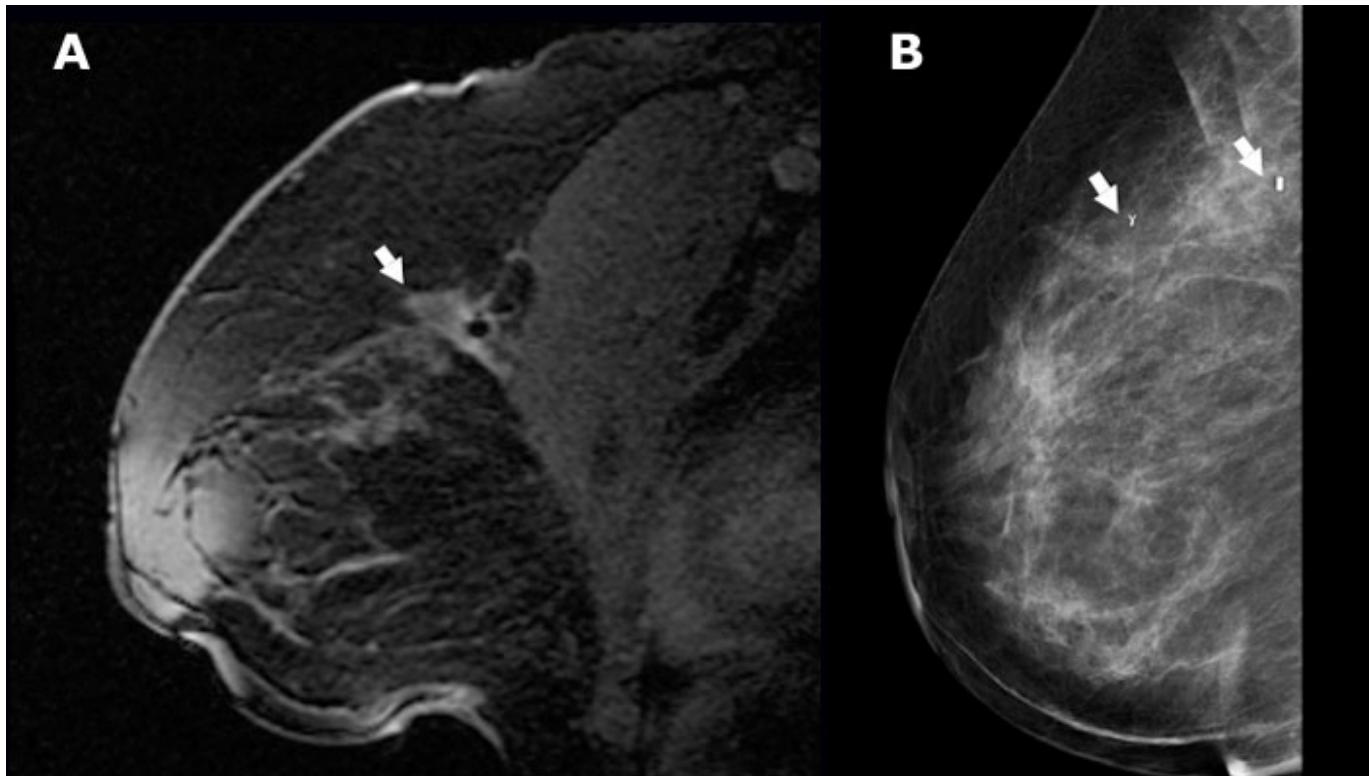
MRI-guided biopsy. The diagnostic MR image (A) demonstrates an area of abnormal contrast enhancement (arrow). Mammogram following the biopsy (B) shows the clips (arrows) placed to mark the biopsy site.
